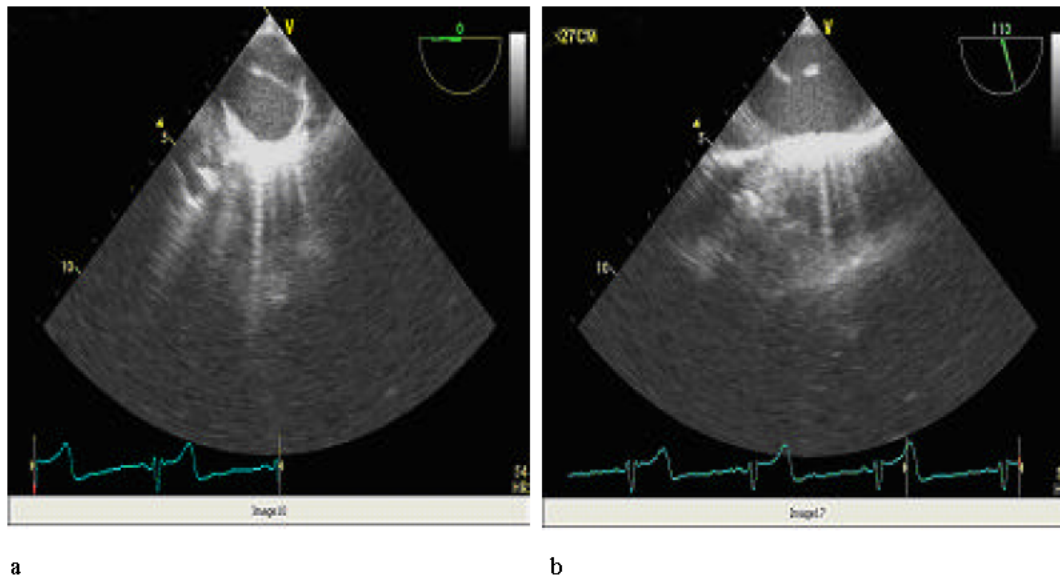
Upper transesophageal view on 0° and 90° showed localized dissecting flap
